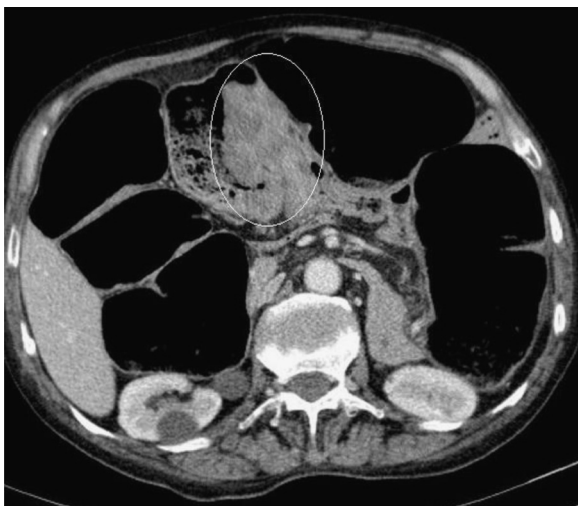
Axial contrast-enhanced CT scan shows an eccentric large mass with luminal narrowing (in circle).
